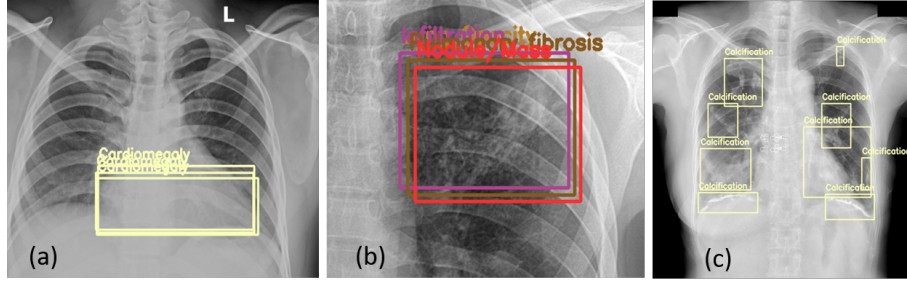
Chest x-ray images described the complexity of radiologists' annotations on lesion areas in the VinDr-CXR dataset.
